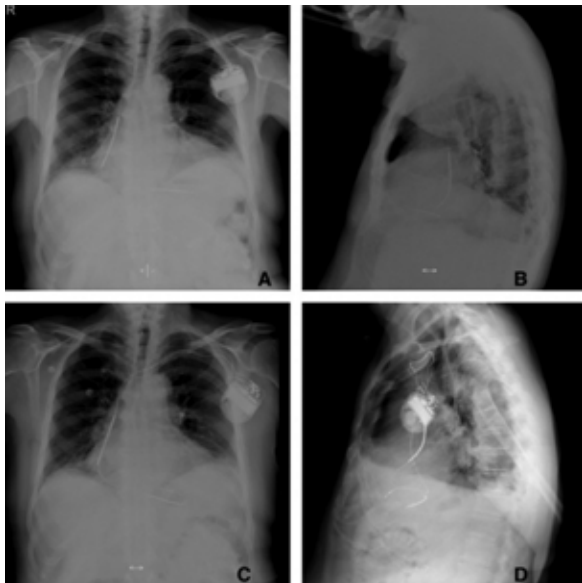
(A, B) Shows Chest x-ray VVI ICD in middle cardiac vein before the procedure, (C, D) shows implantation of pace-sense lead to the right ventricle, double leads are seen in Chest x-ray.
